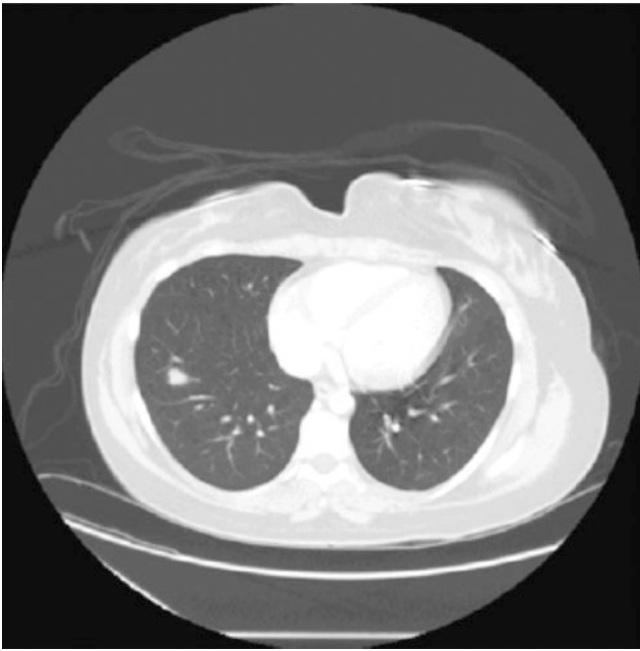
Imaging of the lung bases, obtained as part of an abdominal CT, reveals an approximately 1.5 cm nodule in the right lower lobe
